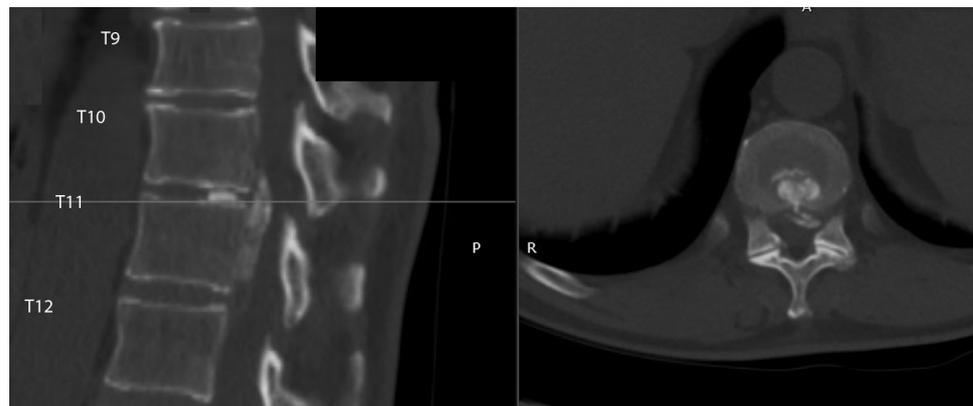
CT scan revealing calcified lesion at T10–T11.
